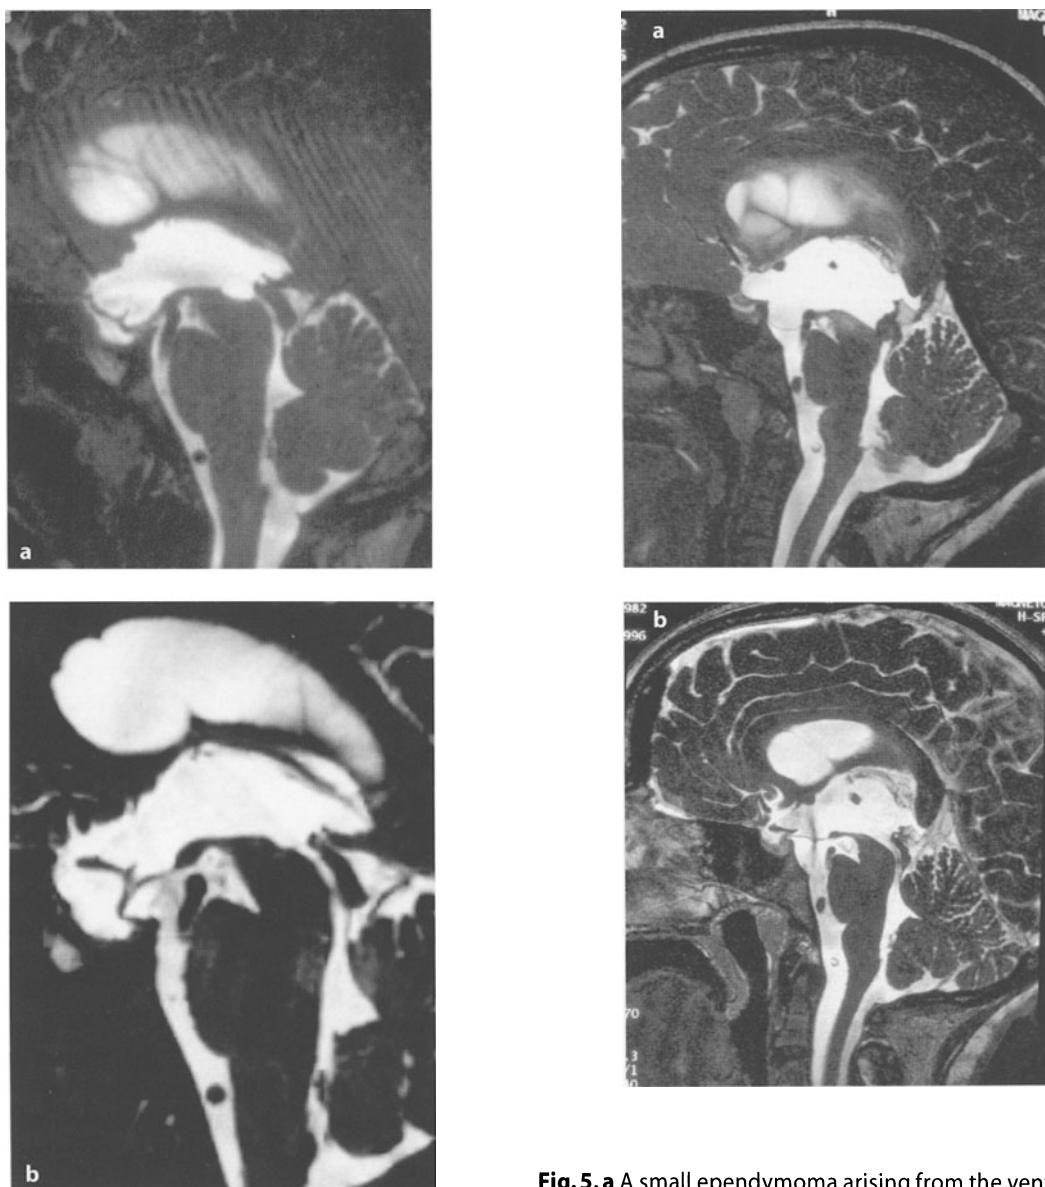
a Intraventricular cyst obstructing the iter. This lesion was invisible on thin T2-weighted conventional FSE images. b The lesion has disappeared after neuroendoscopic cyst puncture. The NTV is patent
